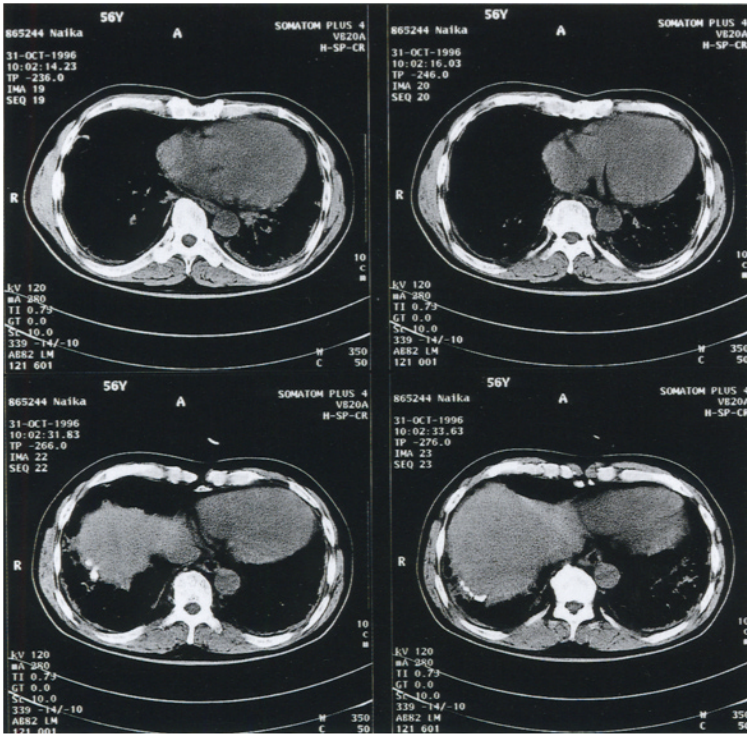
CT images with mediastinal window setting demonstrate diffuse pleural thickening. Calcified plaque is noted on the right hemi-diaphragm
